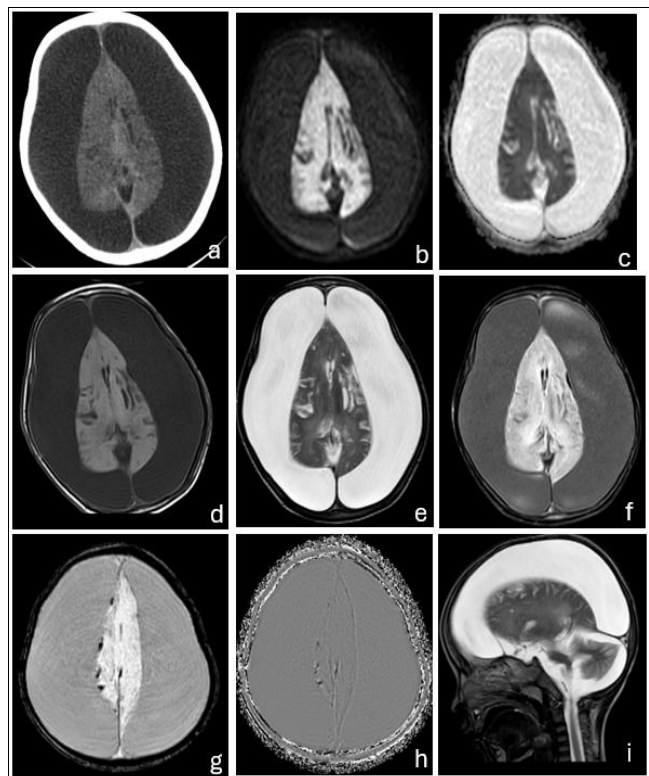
Axial non-contrast CT image (a), diffusion-weighted image (DWI) (b), apparent diffusion coefficient (ADC) map (c), T1-weighted image (d), T2-weighted image (e), fluid-attenuated inversion recovery (FLAIR) image (f), susceptibility-weighted image (SWI) (g), filtered phase image (h), and sagittal T2-weighted image (i) demonstrate large bilateral chronic subdural
